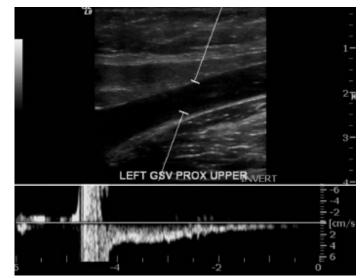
Doppler ultrasound image shows reflux lasting 2.5 seconds, indicative of venous insufficiency in the left great saphenous vein.
